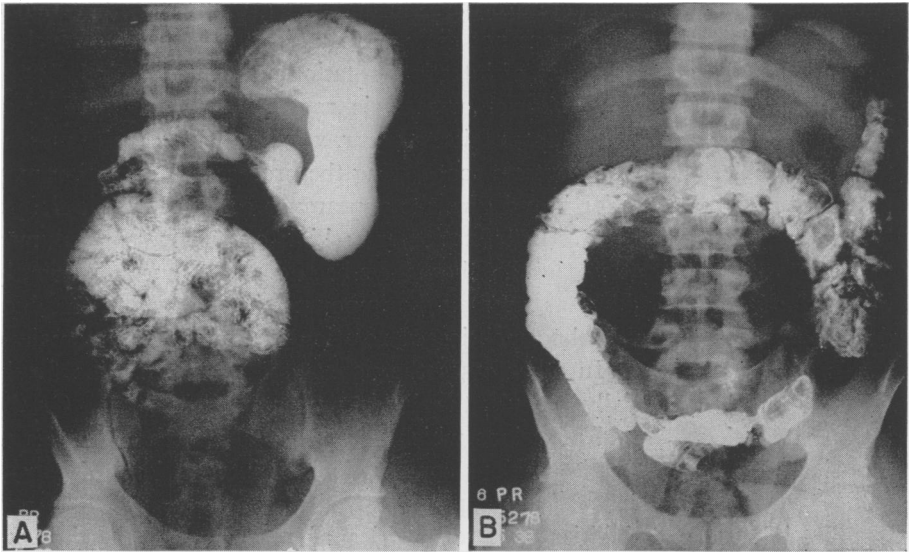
Roentgen rays of the barium filled stomach and intestinal tract in a patient (Case 6) with large internal hernia. (A) The small intestine appears to be enclosed in a circular pocket in the center of the abdomen. (B) This pocket is surrounded by colon of the midgut loop (right half of the colon). The splenic flexure and descending colon (hindgut) are normally placed.
